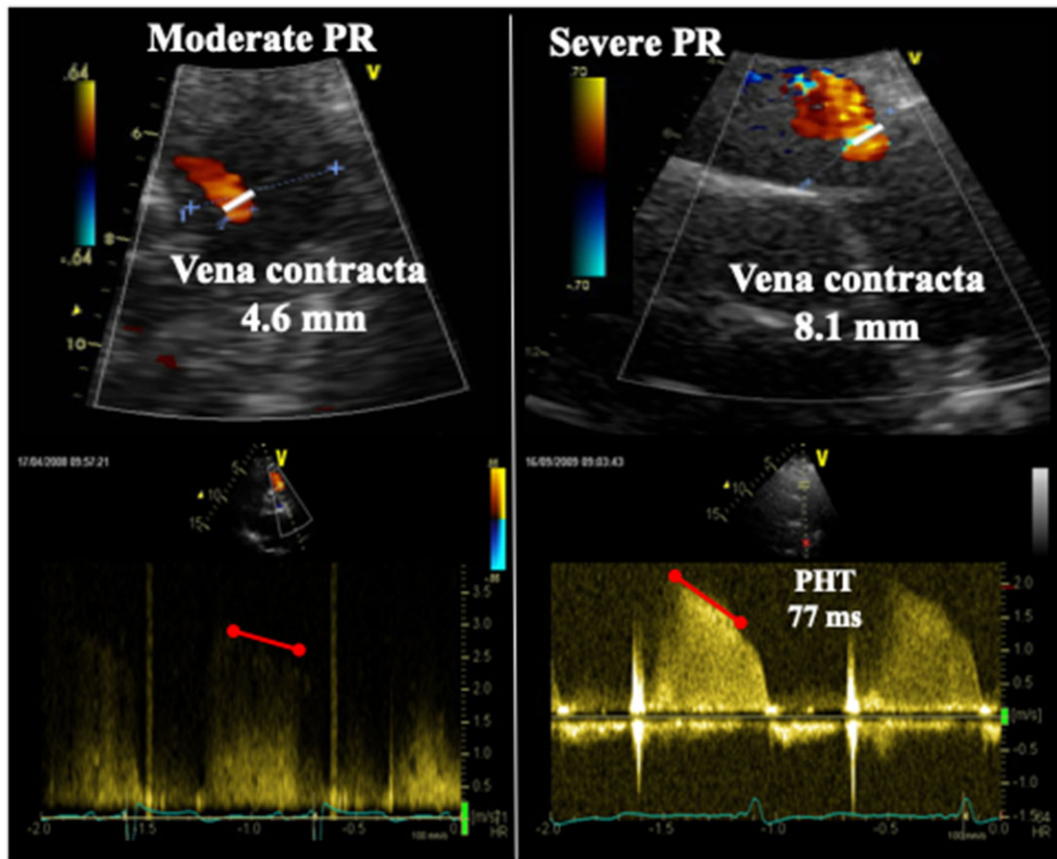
Assessment of PR severity by using colour-flow imaging. *Top:* Measurements of the right ventricular outflow tract dimension (RVOT) and regurgitant jet width in two patients with TR. *Bottom:* continuous wave Doppler recordings.
